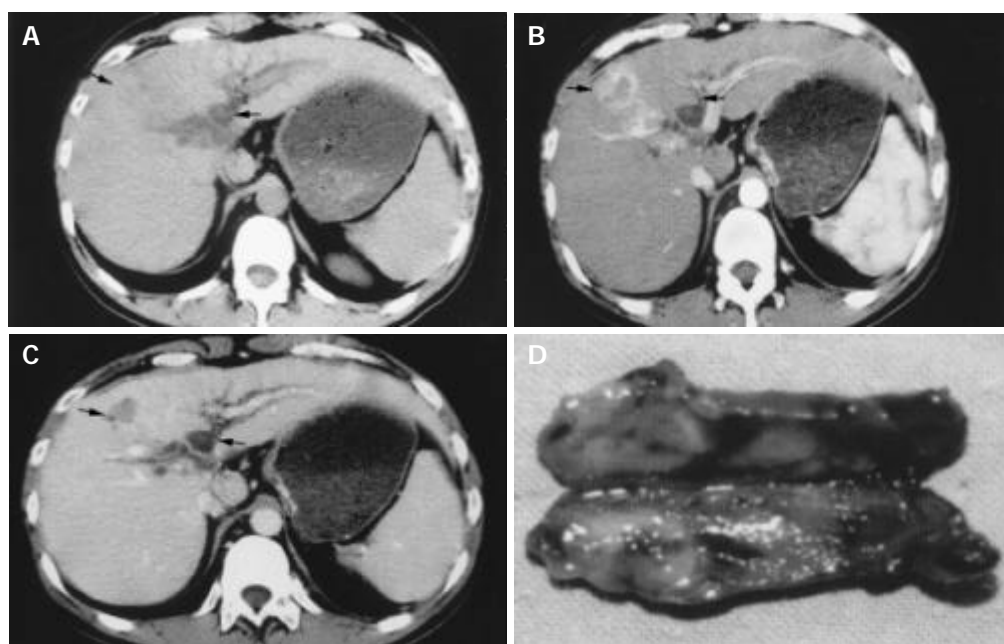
The hepatocellular carcinoma (HCC) with tumor thrombosis in common bile duct. A-C: The three phases of CT scan. One small HCC with rich arterial blood flow is shown in the left medial lobe of liver (arrow), with the intrahepatic bile duct of both sides and common hepatic duct dilated obviously (arrow). D: The tumor thrombosis removed from the common bile duct of this HCC patient.
